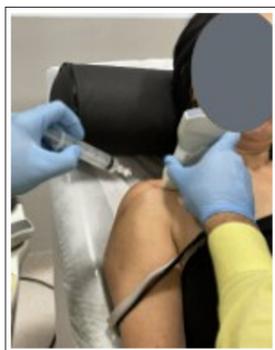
The patient is seated, with the physician positioned behind. A linear ultrasound probe is placed in a transverse/oblique plane, and the needle is introduced from medial to lateral
